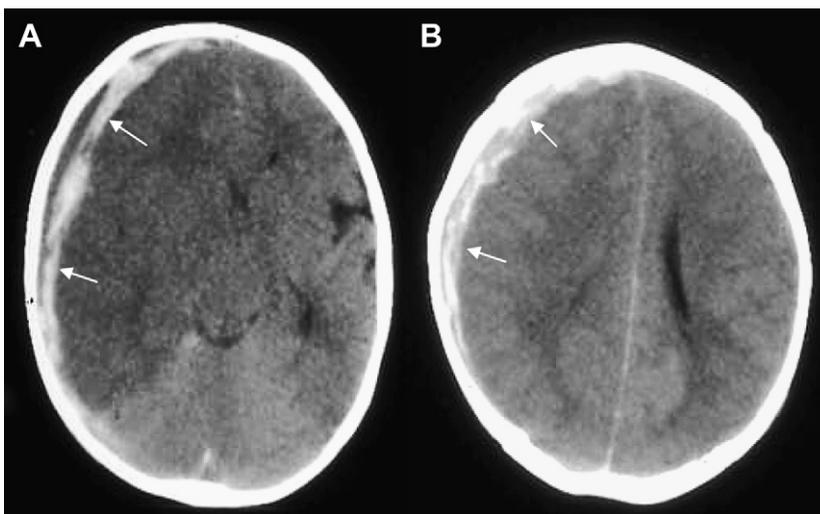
Eight-month-old infant with triad and alleged NAI; also, right occipital skull fracture (age indeterminate; not shown) and 4- to 6-week-old wrist fracture. Hyperacute right SDH versus chronic SDH with rehemorrhage? CT (A, B) shows mixed high- plus low-density right extracerebral collection (arrows) with right cerebral edema, mass effect, and left shift. Question of subdural membrane on autopsy.
